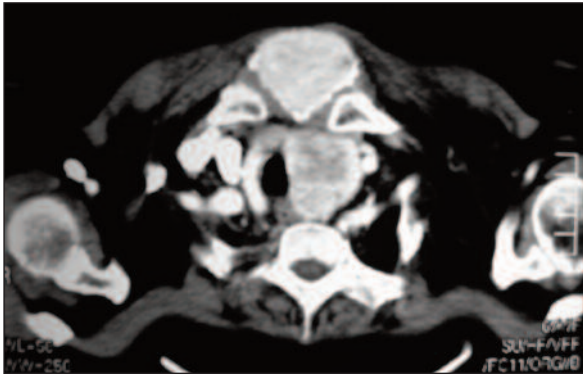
CT of coronal section: Computed tomography scan of the neck and thorax showed soft tissue swelling with destruction of the underlying sternum.
